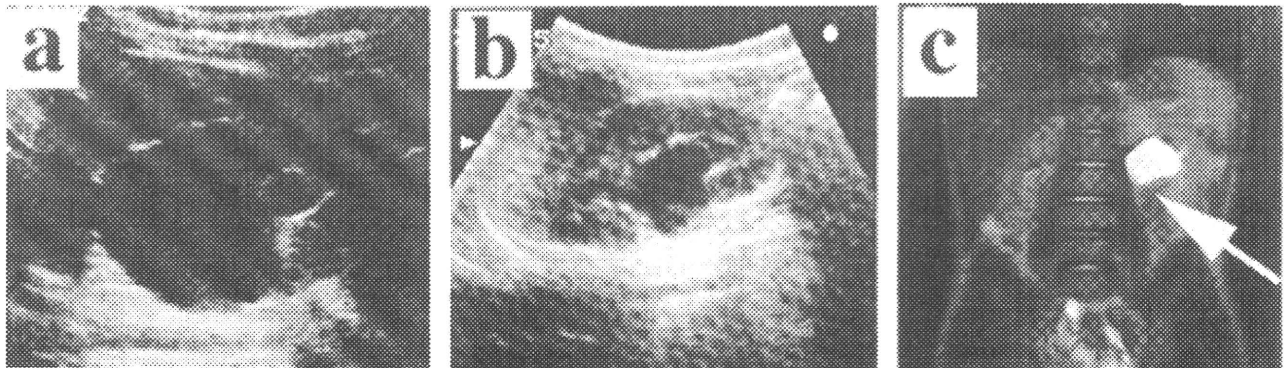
(a) Ultrasonogram taken at 7 months of age. Pelvic dilatation was prominent and hydronephrosis had apparently worsened. (b) Ultrasonogram taken at 9 months of age. Pelvic dilatation improved compared to that at 7 months of age. (c) Magnetic resonance imaging taken before dismembered pyeloplasty: At the ureteropelvic junction there was some irregular texture detected (arrow).
